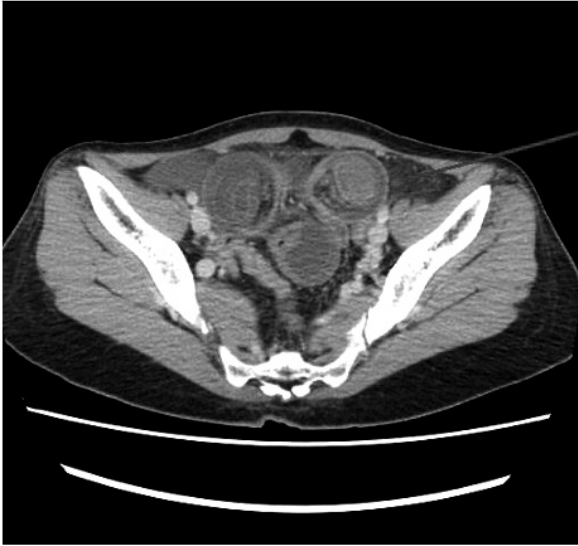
Axial CT image shows multiple concentric rings with the central cylinder resulting in a target sign (arrow).
